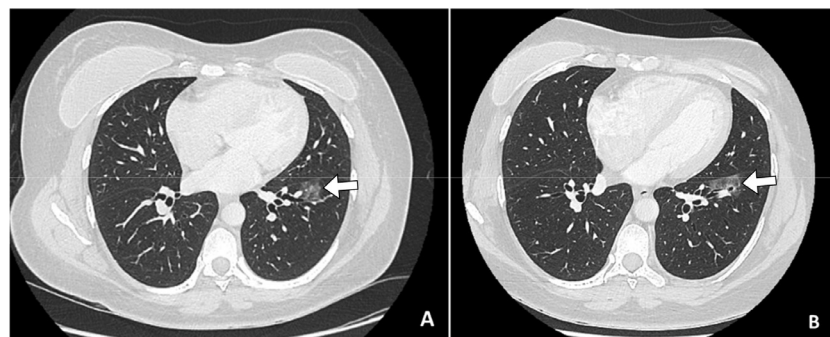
Lung computed tomography of (A) 2018: In the anterior region of the apical segment of the left lower lobe area with increased density in ground-glass of 20 × 18 mm with a central cavitation with no continuity with a structure of the airway and (B) 2021: Ground-glass lesion located in the anteromedial basal segment of the left lower lobe, which has increased in size compared with previous studies, probable neoplastic etiology (adenocarcinoma with lepidic pattern).
